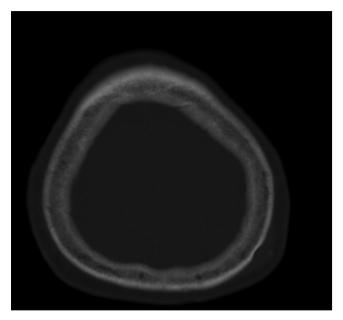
Bone window of the same CT scan showing the outer cortex of skull erosion at the left parietal area.
